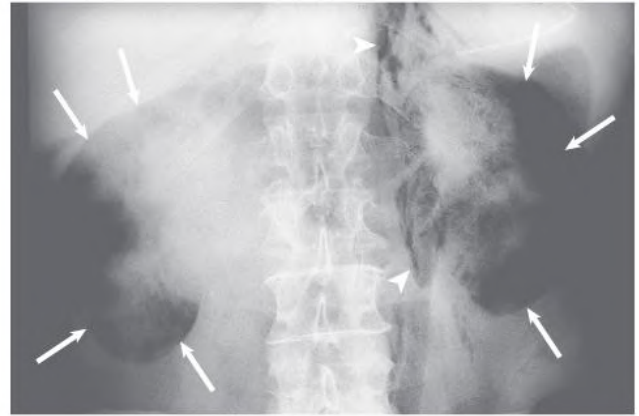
Emphysematous Pyelonephritis. A plain radiograph in this febrile patient with diabetes reveals diffuse gas formation throughout both kidneys (outlined by arrows) and gas dissecting in the left retroperitoneal space (arrowheads). (Courtesy W. Bush, University of Washington, Seattle.)
